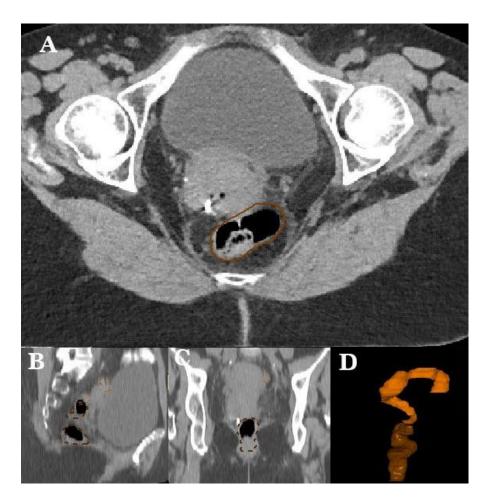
CT, rectum contour (brown) and sigmoid contour (orange), A :axial view, B : Sagital view, C : Coronal view, D : 3-D reconstitution
